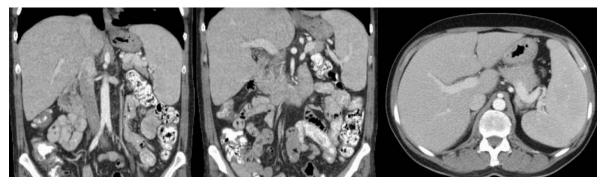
Abdominal ultrasonography and computed tomography (CT) scans indicated splenomegaly, measuring 165 mm.
